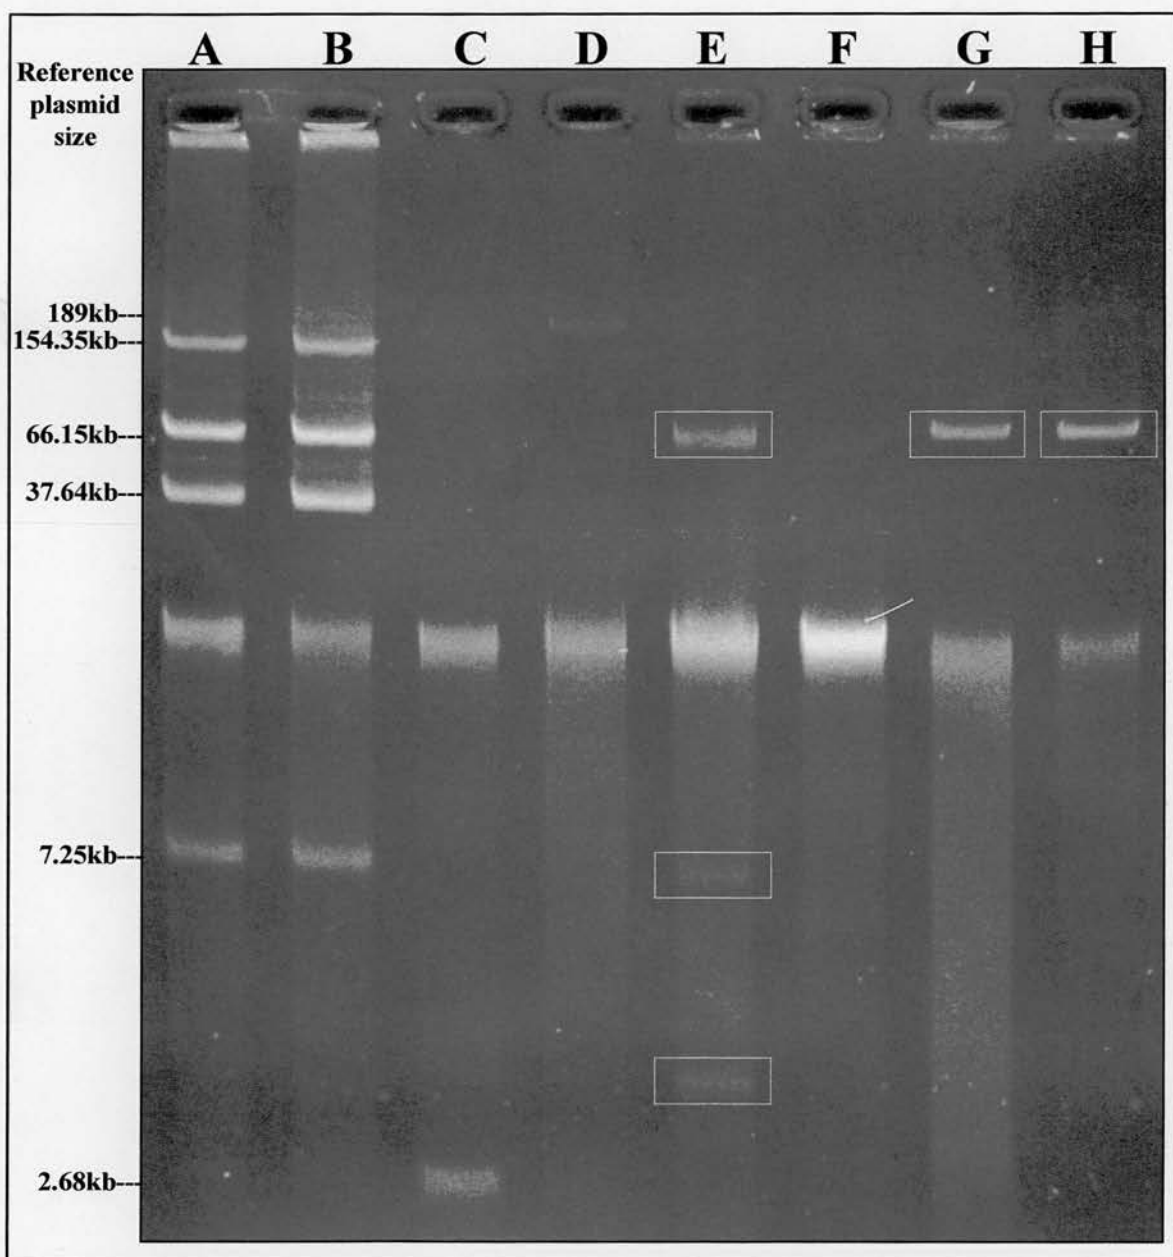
Agarose gel 127: Lanes A and B - reference plasmids from strain 39R861. Lane C - pUC9 reference plasmid. Lane D - RTS 1 reference plasmid (the sizes of the reference plasmids are shown on the left). Lane E - donor *Escherichia coli* CT 73 showing three plasmid bands (highlighted □). Lane F - recipient *Escherichia coli* J62-2 (no plasmids). Lanes G and H - transconjugants each showing one plasmid band (highlighted □) at the level of the largest plasmid (c. 62 kb) of the donor representing transfer of this plasmid from the donor *Escherichia coli* CT 73.
